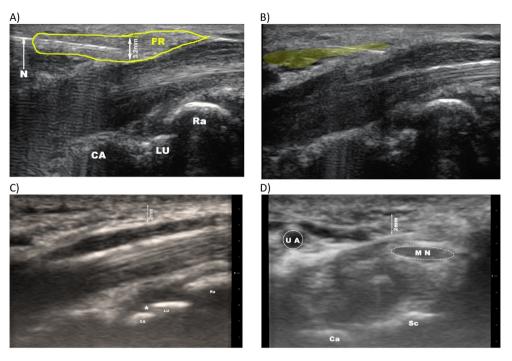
Sonographic assessment of the carpal tunnel condition, following the intra-flexor retinaculum.
